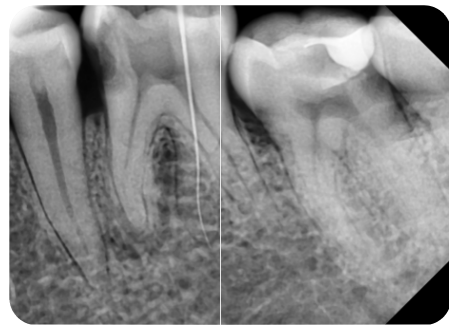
Radiograph with RE in the middle
